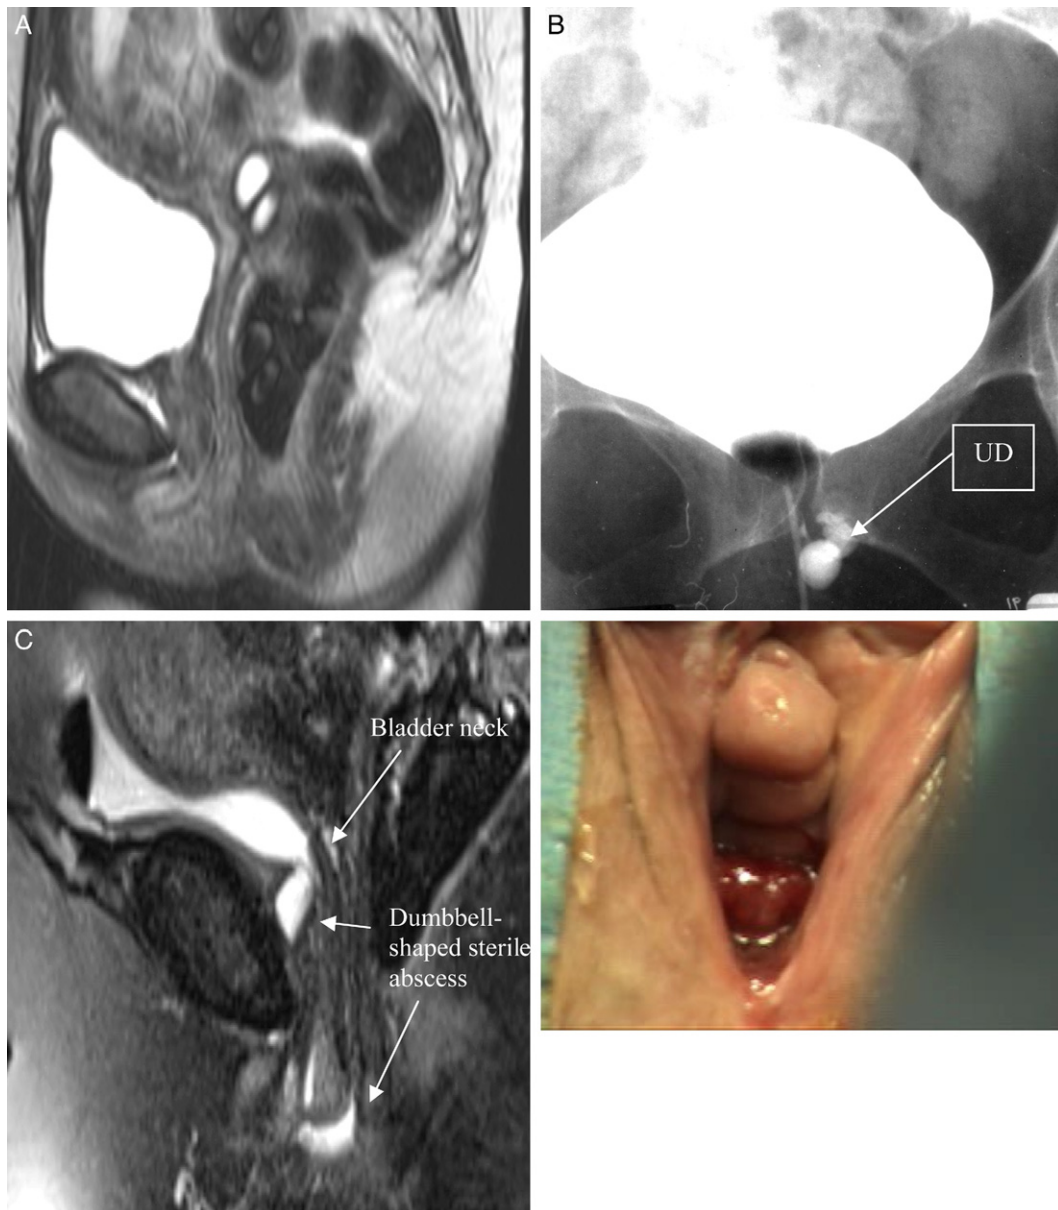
Inaccurate UD diagnosis. A and B, in patient 1 UD was obvious at operation and on VCUG but no MRI findings caused UD suspicion, perhaps due to lack of contrast medium. A, MRI. B, VCUG shows anterior vaginal wall, similar to surgical view. C, patient 17 was diagnosed with UD by MRI but had dumbbell-shaped sterile abscess. No communication with urethra was seen and cavity was filled with thick white urethral bulking agent fluid. When abscess proximal portion was compressed with finger, distal portion protruding from meatus became tense.
